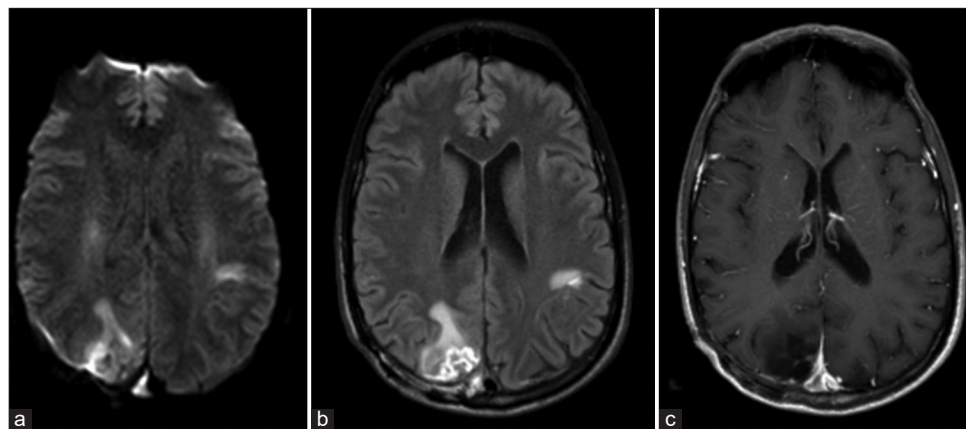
A brain magnetic resonance imaging was done 2-month postoperatively. Axial (a) Diffusion-weighted image, (b) FLAIR, and (c) contrast-enhanced T1-weighted images showing postoperative changes noted in the right parietal and occipital lobes with areas of gliosis and focal volume loss. Nodular areas of enhancement are seen at the surgical site, consistent with scarring-no evidence of residual disease or tumor recurrence.
